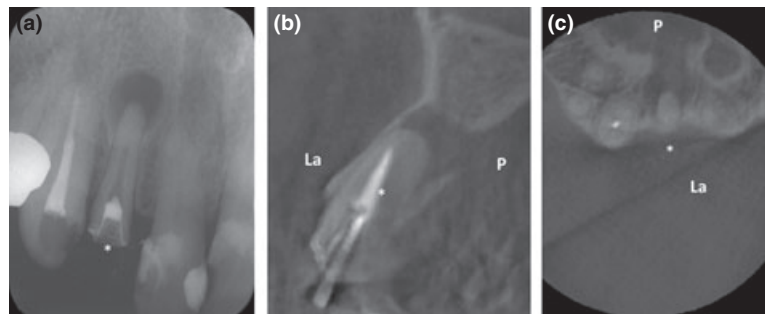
Type III: A periapical bone defect was observed on the palatal side of the bone around the apex of the maxillary right lateral incisor (*). (a) Periapical radiograph. (b) Labio-palatal slice image of the CBCT (3DX). (c) Horizontal slice image of the CBCT (3DX). La: labial side. P: palatal side.
